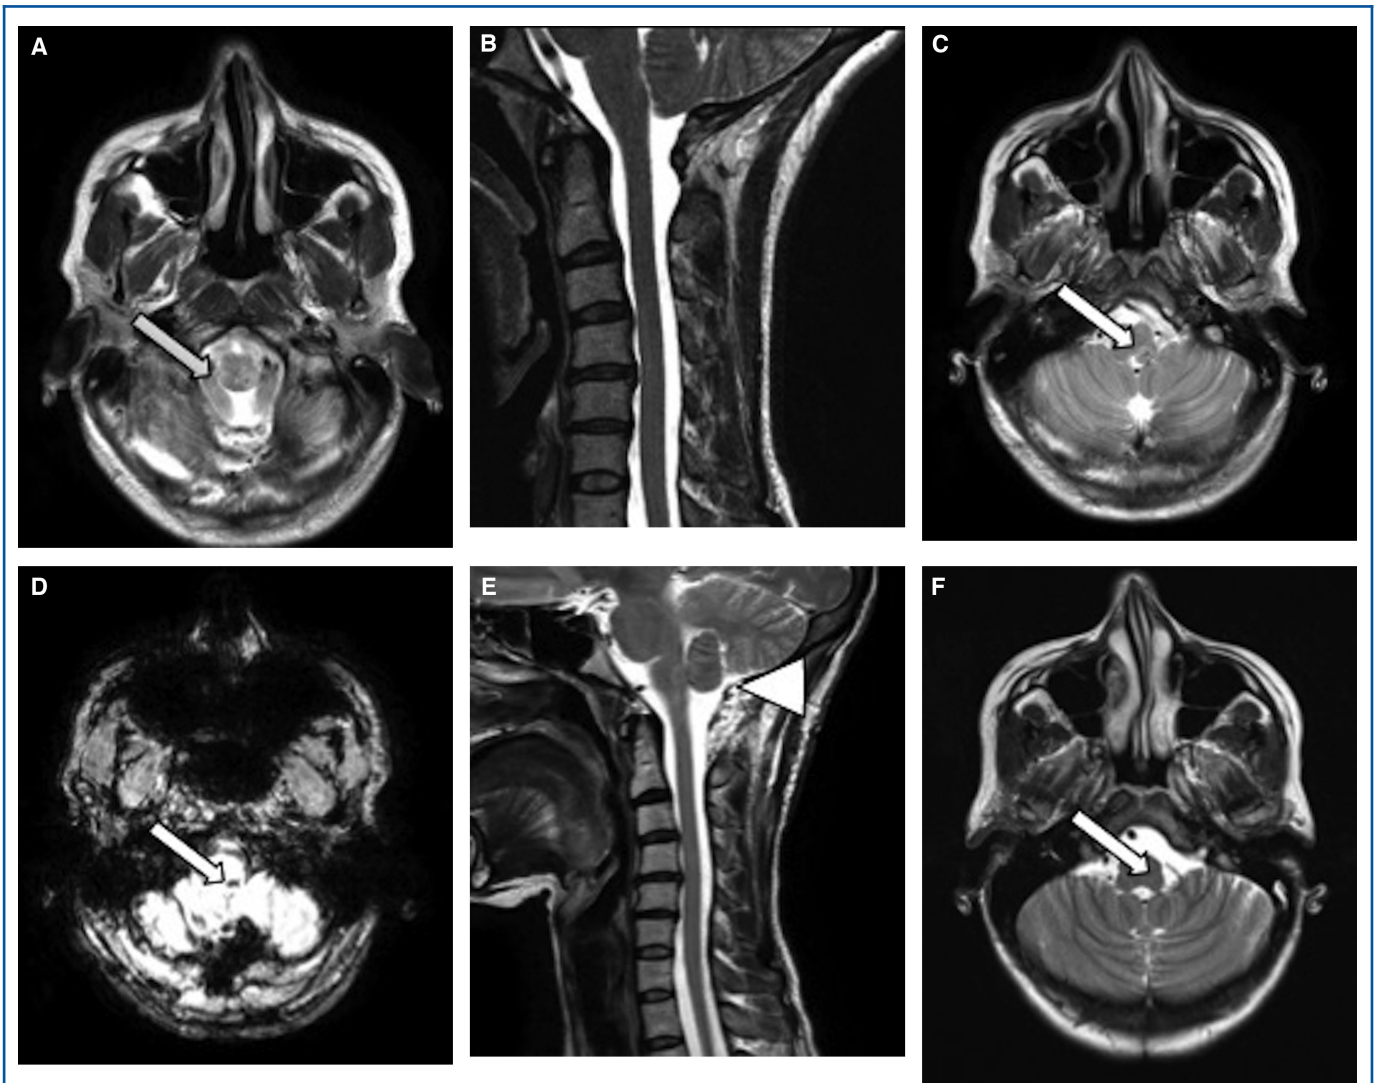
Case 1. A and B, Preoperative T2-MRI axial and sagittal section highlighting ectopic cerebellar tonsil (arrow, A) resulting in crowding of foramen magnum. Immediate postoperative MRI T2 axial C, SWI D, and sagittal E slices with left-side acute medulla hemorrhage (arrows in C and D), with successful tonsillar decompression (arrow head, E). Follow-up MRI T2 axial F section showing resolution of hemorrhage (arrow).
